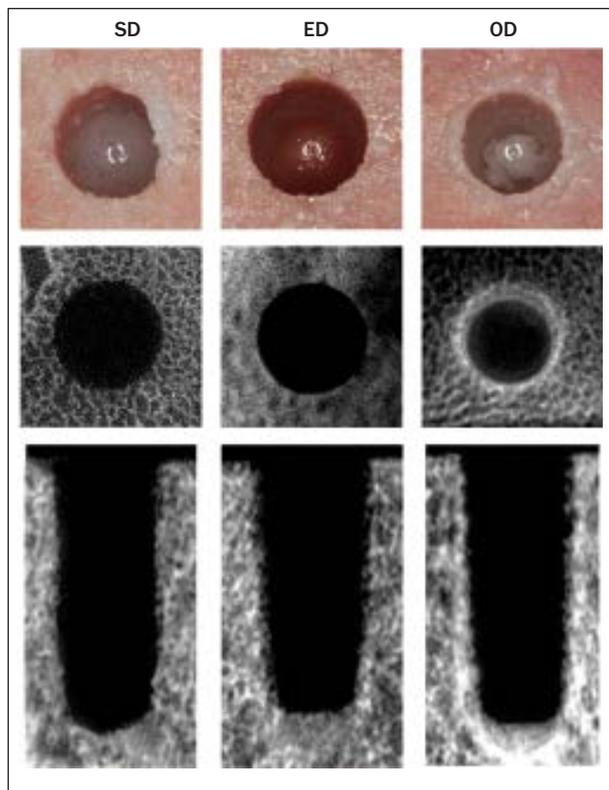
(a) Surface view of 5.8-mm standard drilling (SD), extraction drilling (ED), and osseous densification (OD) osteotomies. (b) Microcomputed tomography midsection and (c) cross section.
